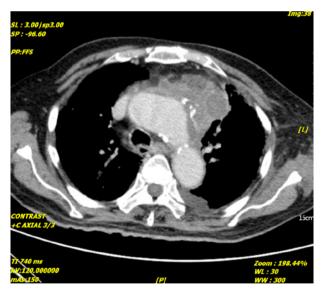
Computed tomography of the chest showed a large left anterior superior mediastinal tumor $(8 \times 6 \times 7 \text{ cm})$ with Surrounding hematoma compressing the trachea (arrow).
